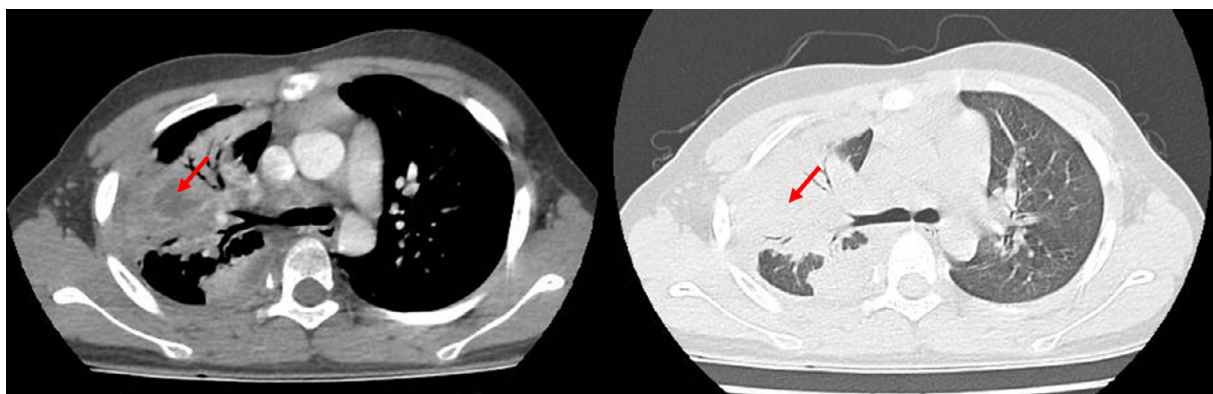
Chest CT scan of the chest reveals a 40 x 46 mm consolidation (arrow) with bronchograms inside the lesion in the right upper and middle lobes, as well as a 46 mm right free-flowing pleural effusion.
